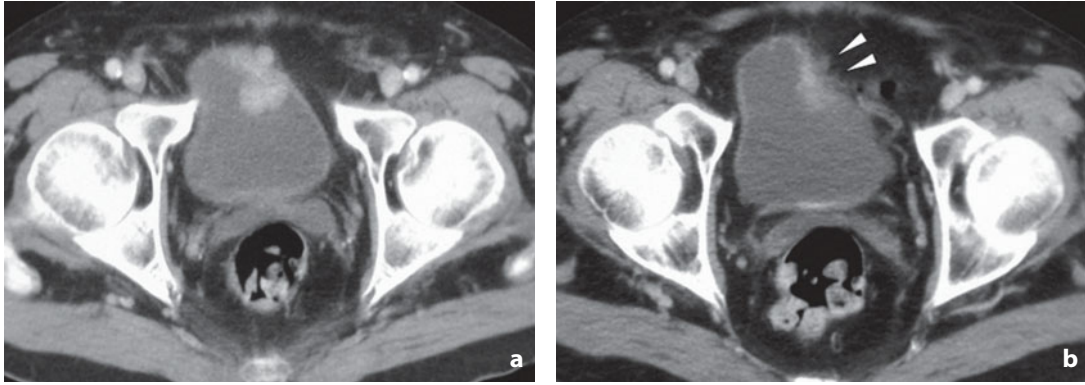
Computed tomography. Bladder cancer. a The mass attached to the left anterolateral wall is moderately enhancing after injection of contrast medium in the venous phase of the dynamic study. b Probable invasion of the perivesical fat (*arrowheads*)
